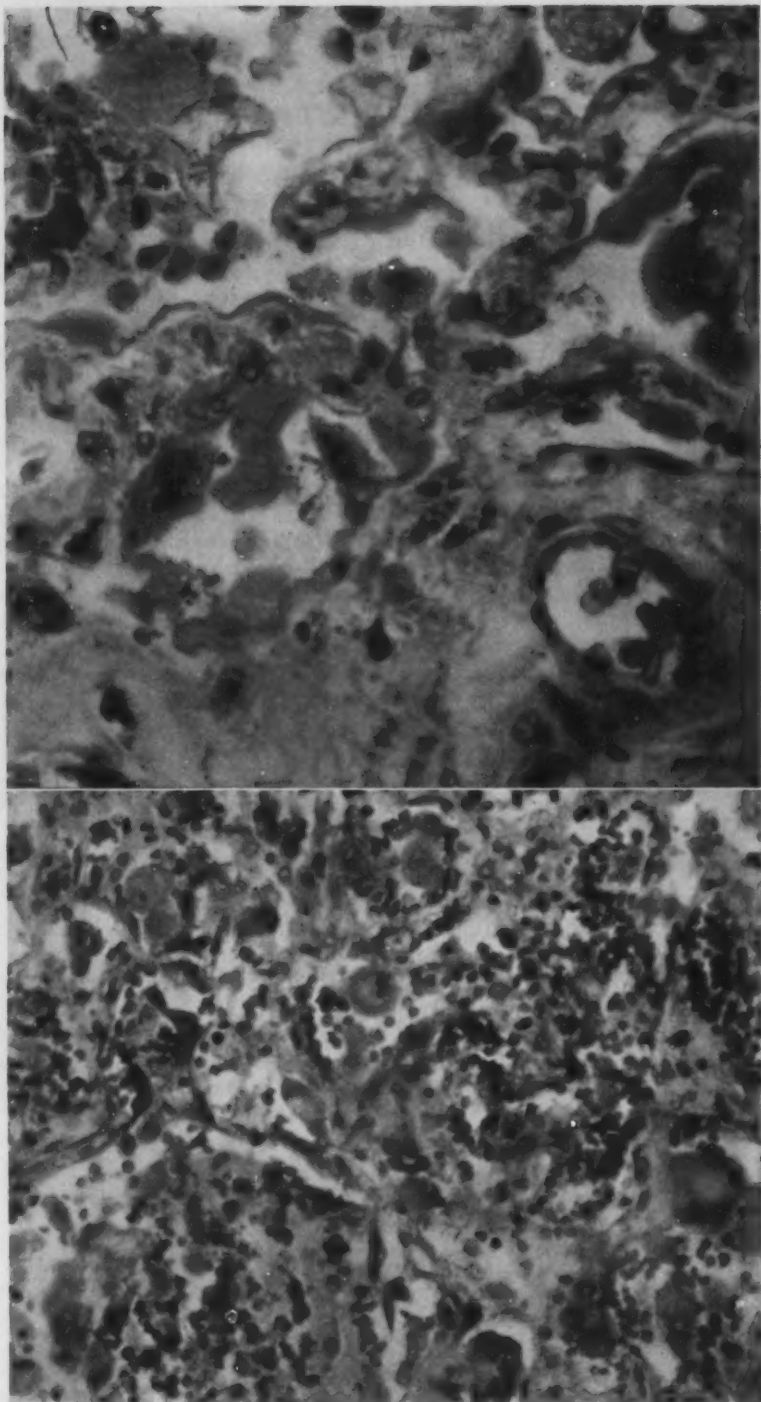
Upper part: Abnormal alveolar lining cells and early hyaline membrane in human lung (same lung as in figure 1) that had been irradiated with 200 kilovolt roentgen rays; $\times 600$. Note the continuity of alveolar cells and membrane and the fusion of membrane and wall. Note also the hyaline thickening of the alveolar walls.
